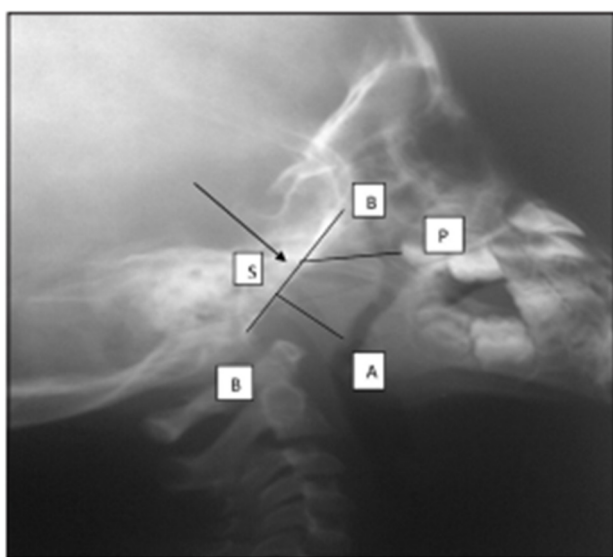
Lateral X-ray of the nasopharynx that shows how adenoidal-nasopharyngeal ratio was determined.
